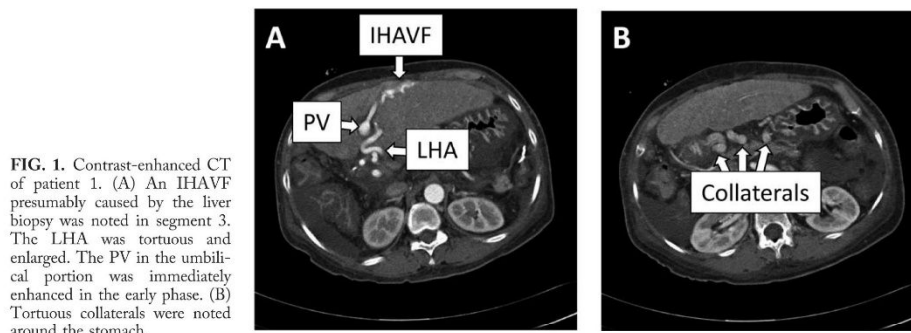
Contrast-enhanced CT of patient 1. (A) An IHAVF presumably caused by the liver biopsy was noted in segment 3. The LHA was tortuous and enlarged. The PV in the umbilical portion was immediately enhanced in the early phase. (B) Tortuous collaterals were noted around the stomach.
